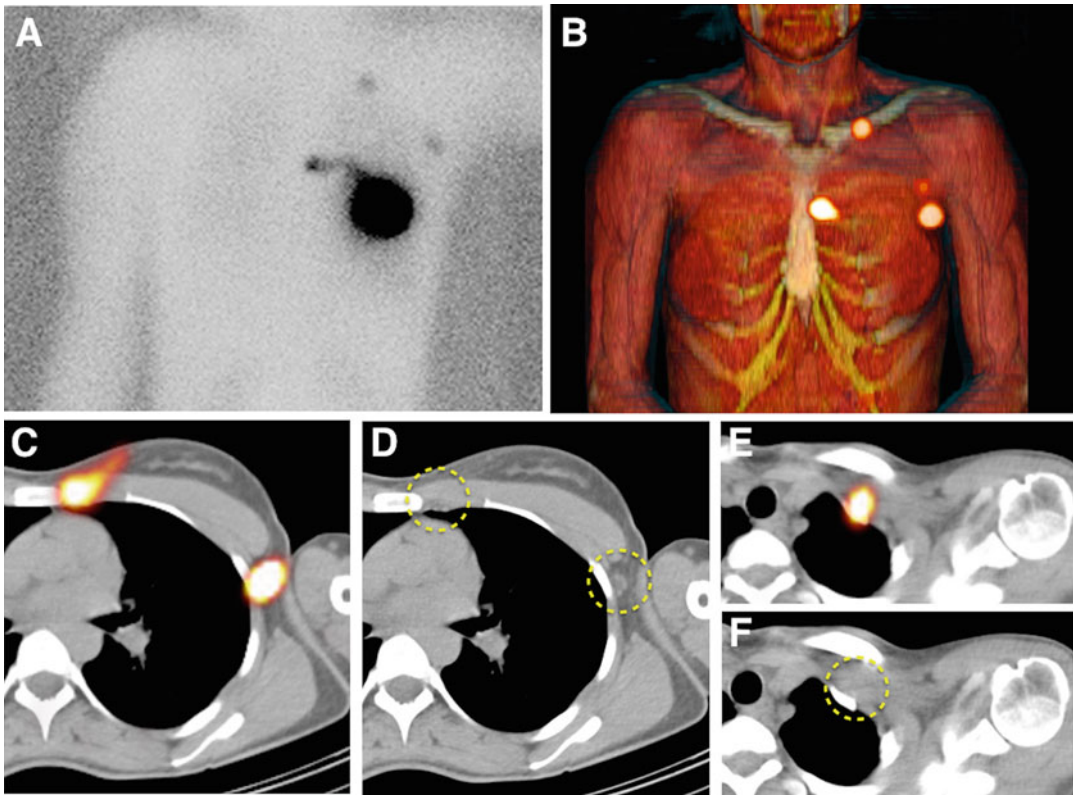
Anatomical sentinel lymph node localization in breast cancer. Following deep injection of ^{99m}Tc -nanocolloidal albumin in the left breast, lymphatic drainage to the axilla, periclavicular area, and internal mammary chain is observed on anterior planar image (a) and on SPECT/CT
